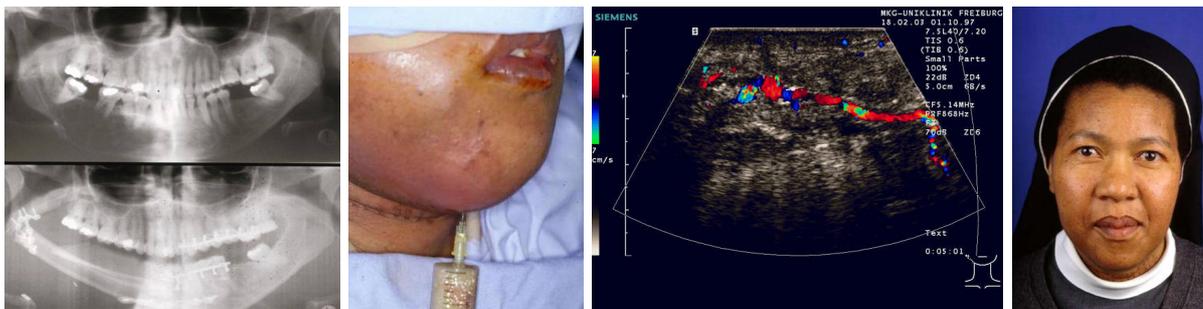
Primary mandibular reconstruction using a fibula flap was performed after resection of an ameloblastoma. Preoperative and postoperative X-ray (Fig.3). At postoperative day ten an abscess had formed next to the free fibula flap (Fig.4). Good perfusion of the anastomosis and the flap was demonstrated using colour duplex sonography (Fig.5). Revisional surgery was not performed. Postoperative view of the patient (Fig.6).
